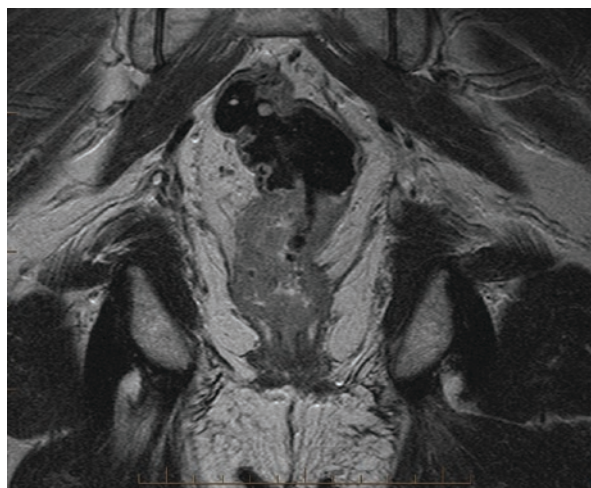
Coronal T2 MRI low rectal cancer
